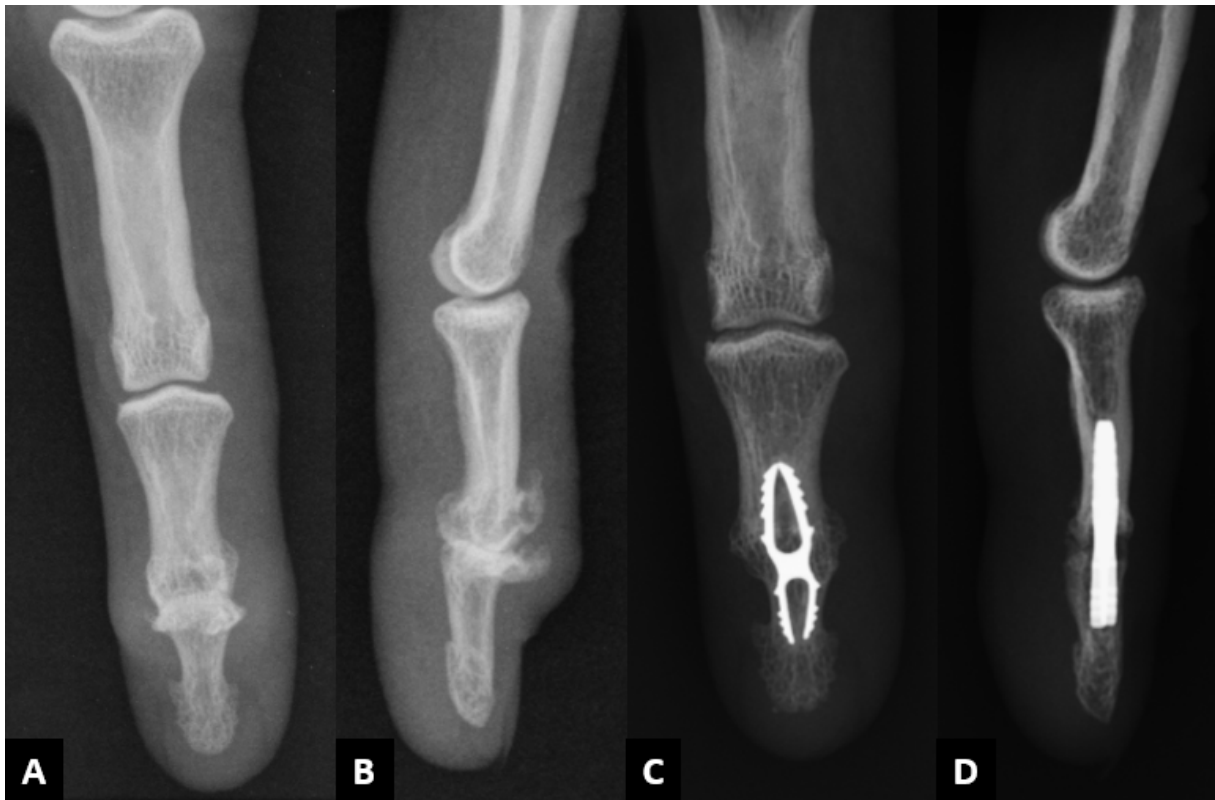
A, B: Preoperative radiographs of a degenerative DIP that underwent arthrodesis with X-Fuse and radiographs at 7 years of follow-up (C, D). The patient is pain-free, and no complications occurred.
